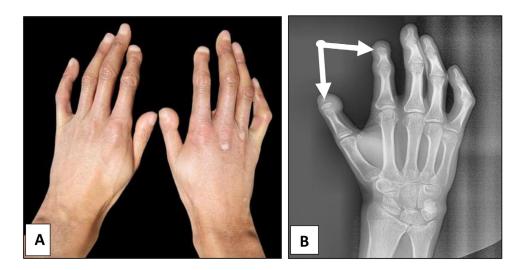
(A) Left and right Hands with short and round tipped terminal finger phalanges; (B) Left hand X-ray showing short terminal fingers phalanges with acroosteolysis (white arrows).
